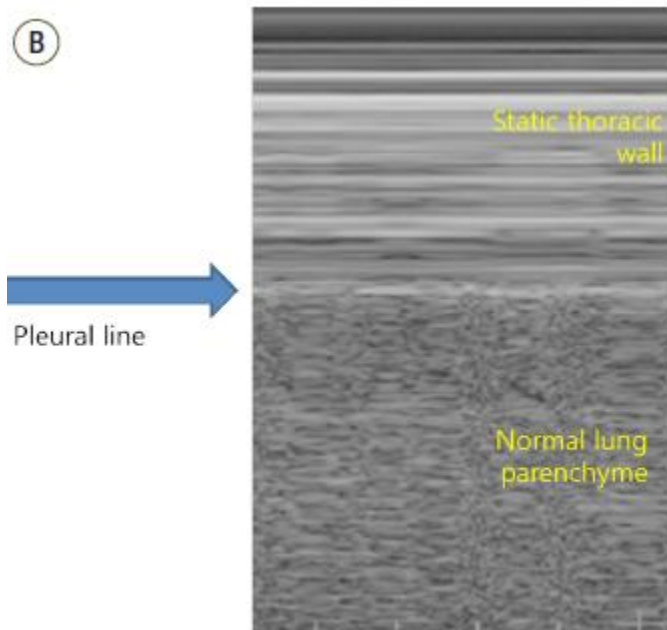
Normal findings of lung ultrasound (B). Normal lung pattern on M-mode: seashore sign. Motionless chest wall generates horizontal lines and lung sliding makes the sandy pattern.
